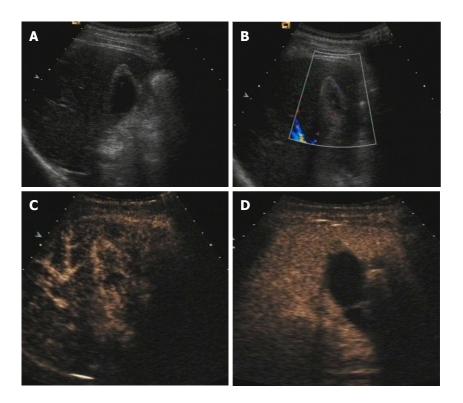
Gallbladder adenomyomatosis in a 62-year-old male patient. A: B-mode sonography showed a heterogeneously hypoechoic lesion on the gallbladder wall, with an intact gallbladder wall; B: Color Doppler ultrasound showed no color Doppler signal in the lesion. According to A and B, a diagnosis of probably benign was made. C: CEUS showed heterogeneously enhanced, with some small nonenhanced areas, on arterial phase; D: CEUS showed heterogeneously enhanced, with some small nonenhanced areas, on venous phase. According to C and D, a diagnosis of benign gallbladder adenomyomatosis was made. CEUS: Contrast-enhanced ultrasound.
